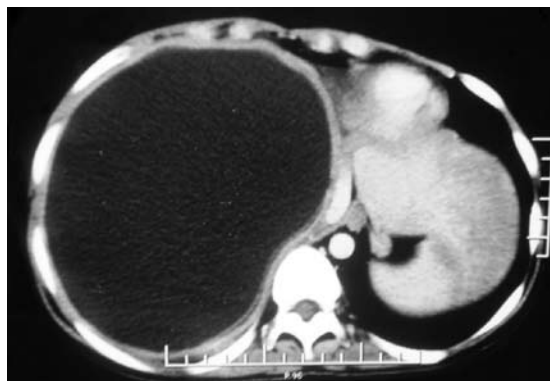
Contrast-enhanced axial CT image of the abdomen shows a large hypodense lesion involving almost the whole of the right lobe of the liver and abutting the right hemidiaphragm. The cyst wall and its contents are non-enhancing.
